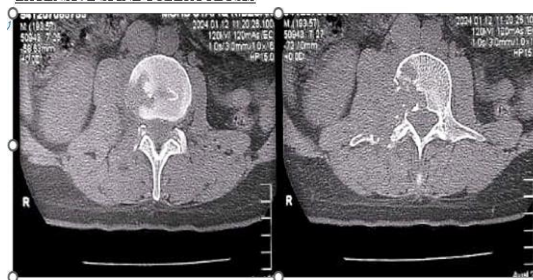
CT SCAN SHOWS OSTEOLYTIC DESTRUCTION OF THE VERTEBRAL BODY
